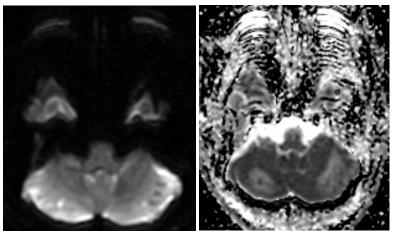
Diffusion restriction lesions in bilateral cerebellum as seen on DWI with ADC correlate.
